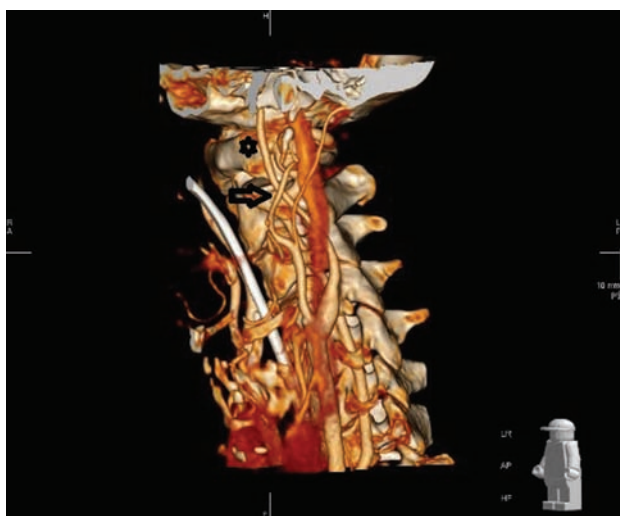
CT angiogram shows a uniformly narrowed cervical portion of left ICA (arrow and star show narrow ICA). CT = computed tomography; ICA = internal carotid artery.
